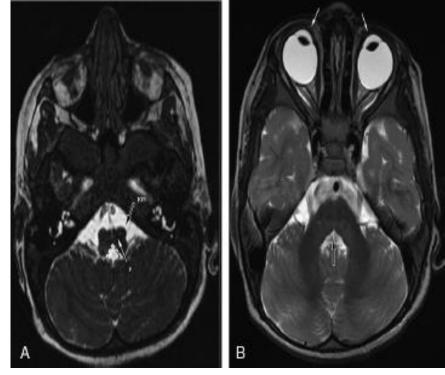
From left to right: A) A) Axial FIESTA Sequence showing butterfly configuration of the medulla with midline cleft. Also of note is the prominent Inferior Olivary Nucleus (ION) (Black Arrow) with respect to Pyramid (P). Furthermore, the white dashed arrows show tenting of the fourth ventricle [1]. B) Axial T2 showing bilateral convergent strabismus. In addition, there is dorsal pontine cleft and absent facial colliculus (Black Arrow) [1] (MRI Brain image from Tyradellis et al. [1])
